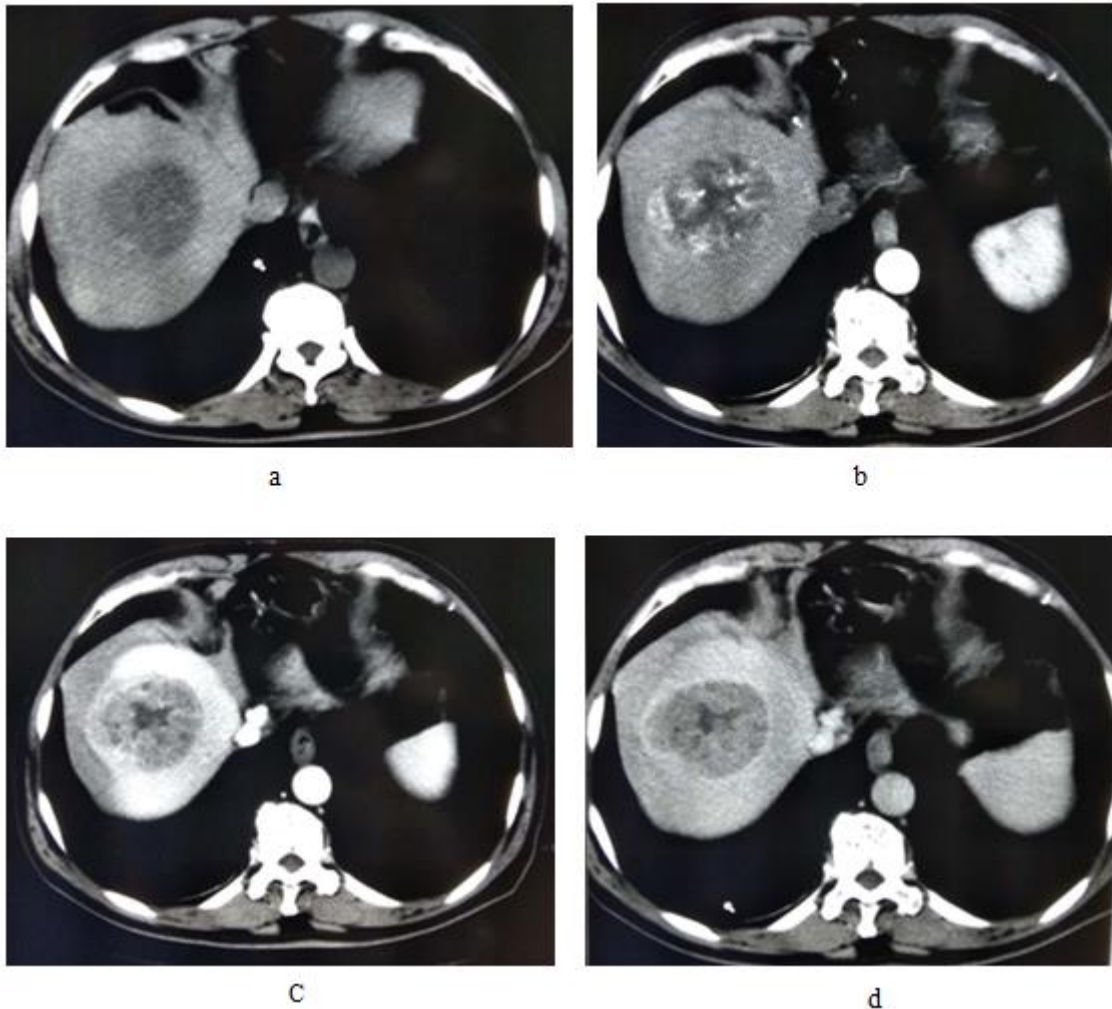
Images in a 63-years-old male with HCC with cirrhosis: multiphasic CT technique. (a) There is hypodensed lesion shown on precontrast CT image. (b) Early arterial phase image shows heterogeneously enhanced mass but not adequately enhancing and generally not useful in detecting HCC (c) Late hepatic arterial phase image shows heterogeneously hyperenhancing mass. Notice enhancement of hepatic artery and portal vein branches in late hepatic arterial phase. Hepatic veins are not enhanced. (d) Relative to liver, mass de-enhances or gets washed out on (d) portal venous phase image. Mass has capsule appearance in venous phases. Notice that hepatic veins are enhanced in portal venous and delayed phases.
